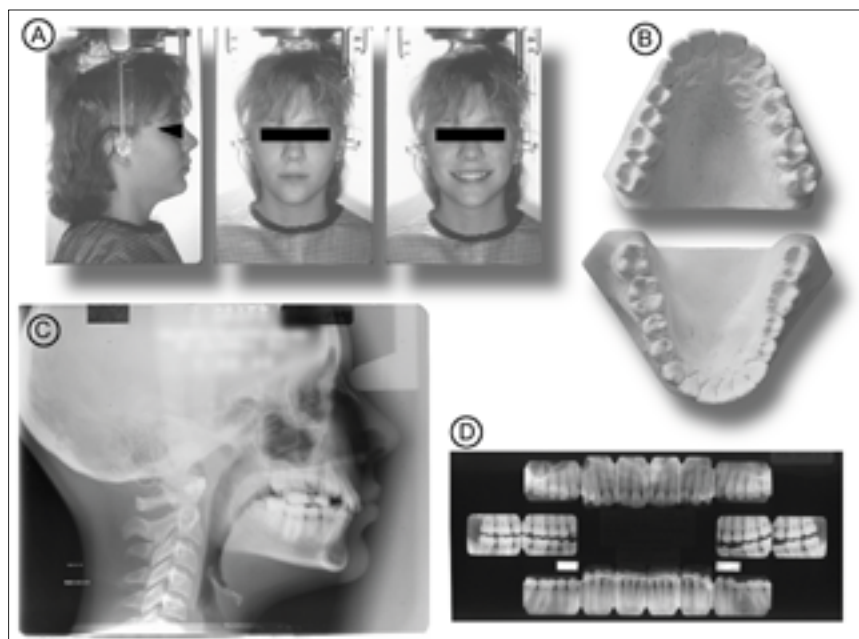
The basic physical records used in classical orthodontic diagnosis and treatment planning. A) Semistandardized facial photographs; b) study casts; c) standardized lateral cephalograms; and d) panoramic and/or intraoral X-ray images.
